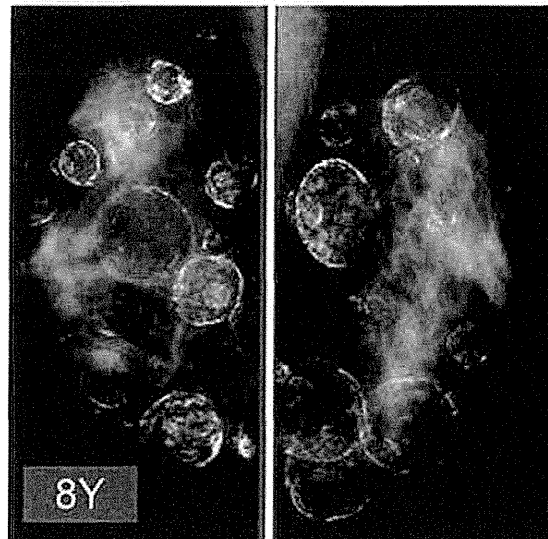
Sequential CT images and mammography of oil cysts. (Left) CT was sequentially taken from a patient (34-year-old woman) with multiple oil cysts in both breasts who did not undergo any removal of the cysts. The size of oil cyst did not change between 3 and 8 years, but calcifications progressed during the period. (Right) Mammography of the same patient at 8 years. Many eggshell-like calcifications are shown. (Modified from Mineda K, Kuno S, Kato H, et al. Chronic inflammation and progressive calcification as a result of fat necrosis: the worst outcome in fat grafting. *Plast Reconstr Surg* 2014;133:1064–72.)
